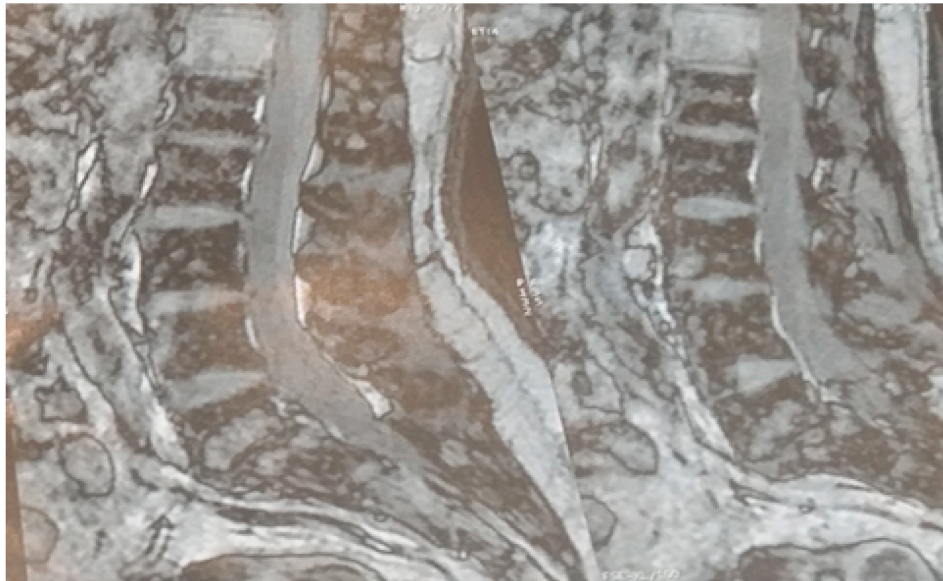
Dorso-lumbar MRI objectifying the two lesions.
